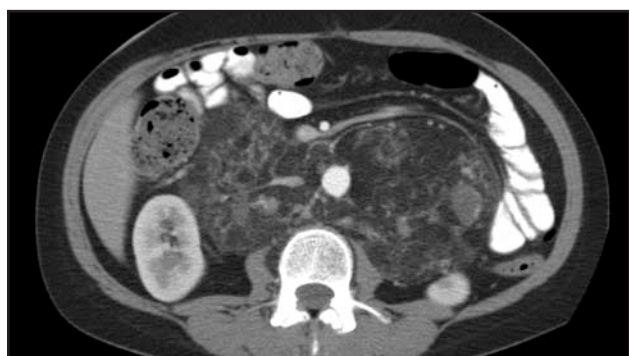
Abdominal CT scan of a patient with LAM. A large angiomyolipoma completely involves the retroperitoneal area causing anterior displacement of the aorta.
